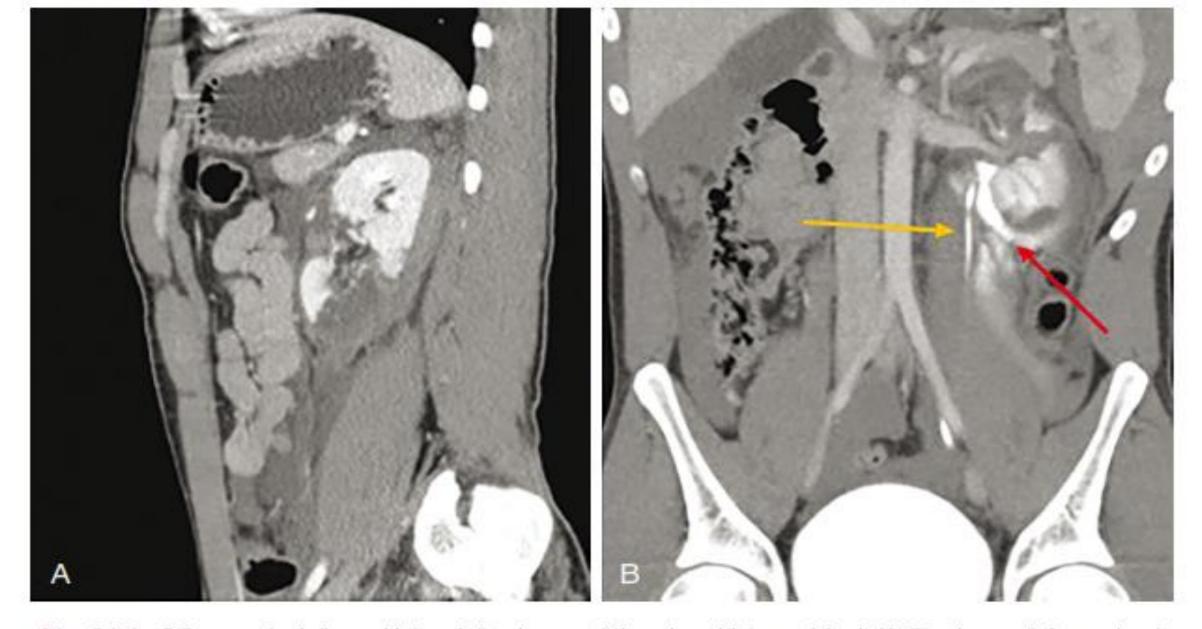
CT scan of a left renal injury following an all-terrain vehicle accident. (A) The immediate contrast phase. (B) Delayed-phase imaging demonstrating a grade IV injury with a normal ureter (yellow arrow) and urinary extravasation (red arrow).
